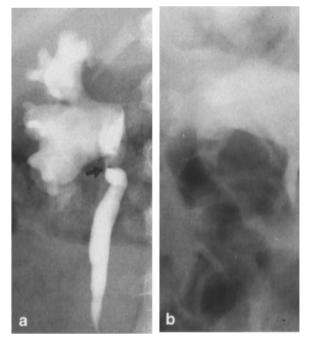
a Preoperative retrograde pyelogram in a 2-yearold boy with recurrent urinary tract infections and mild hydronephrosis suggested by sonography and confirmed by excretory urography. Tight UPJ obstruction is seen (*arrow*). b Six months postoperatively, after Anderson-Hynes type pyeloplasty, remodeled right UPJ funnels without obstruction
